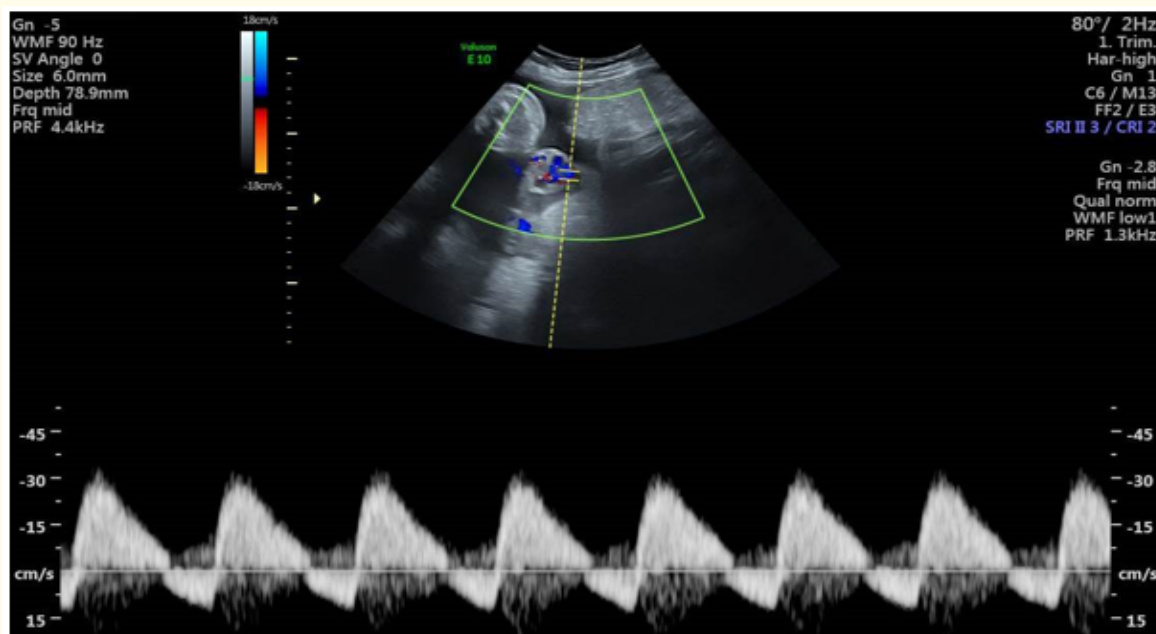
Color Doppler umbilical artery wave form demonstrating reversed end diastolic frequency.
